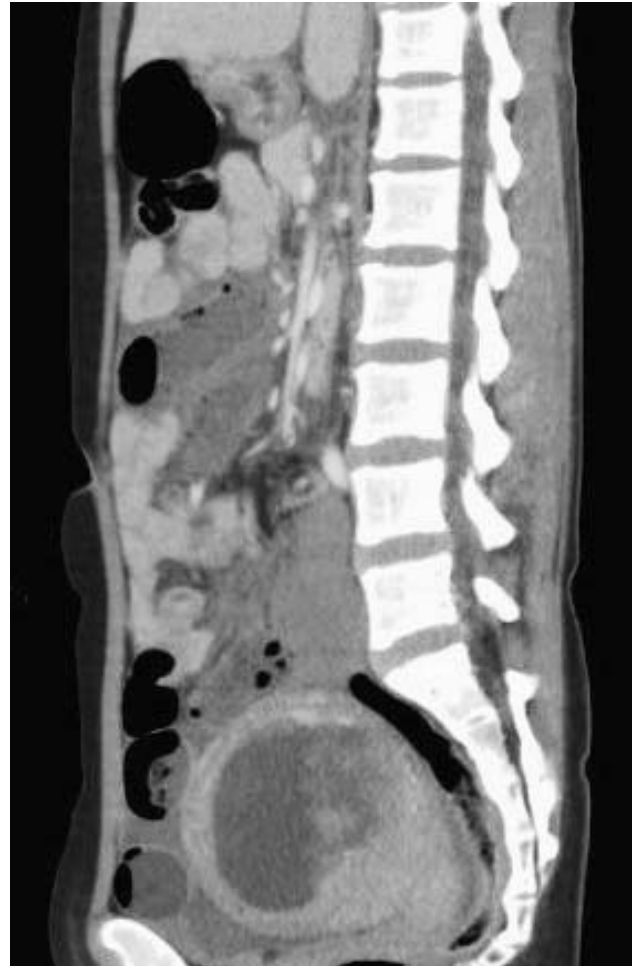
(c) Contrast-enhanced CT scan (sagittal view).
